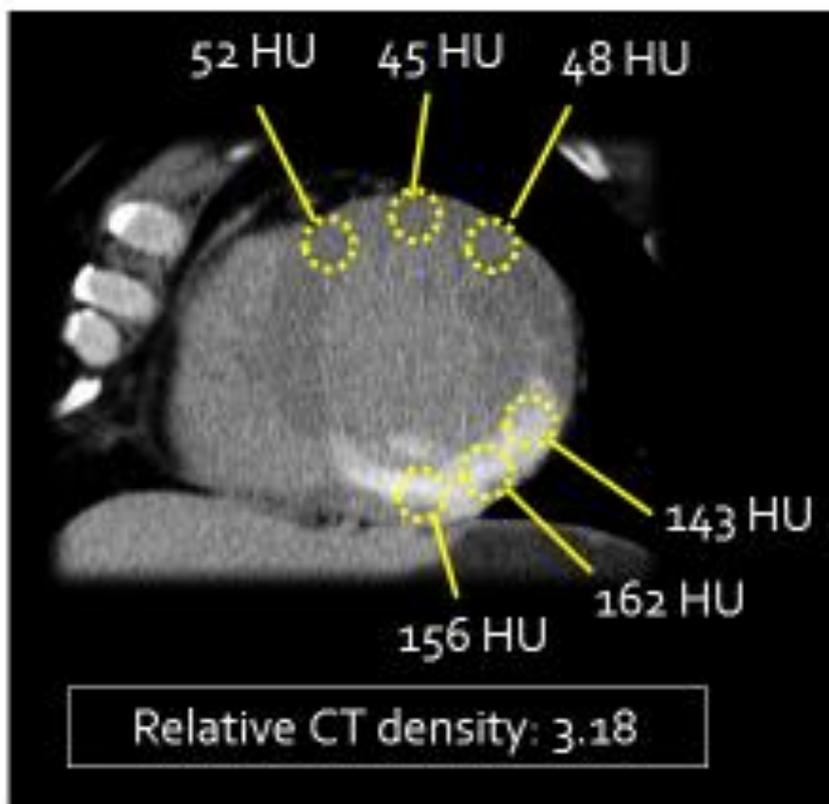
Short-axis DE-CT of a 49-year-old man. The CT density values of the contrast-enhanced myocardium and non-enhanced myocardium were measured from at least 3 ROIs with the dimension of myocardial thickness. To normalize the CT values, the relative CT density was calculated as the rate of average density of contrast-enhanced myocardium to that of non-enhanced myocardium. In this image, the relative CT density was calculated to be 3.18.
